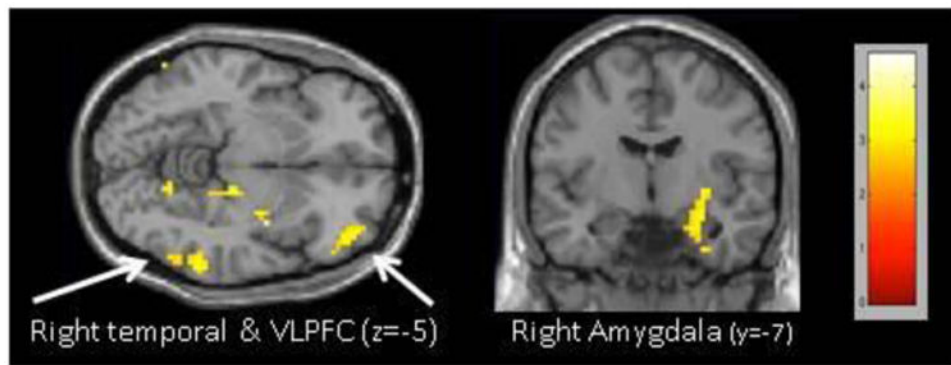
MR images showing greater neural activity in right middle temporal gyrus, RVLPCF, and right amygdala for SAD during Neutral>Rejection.
